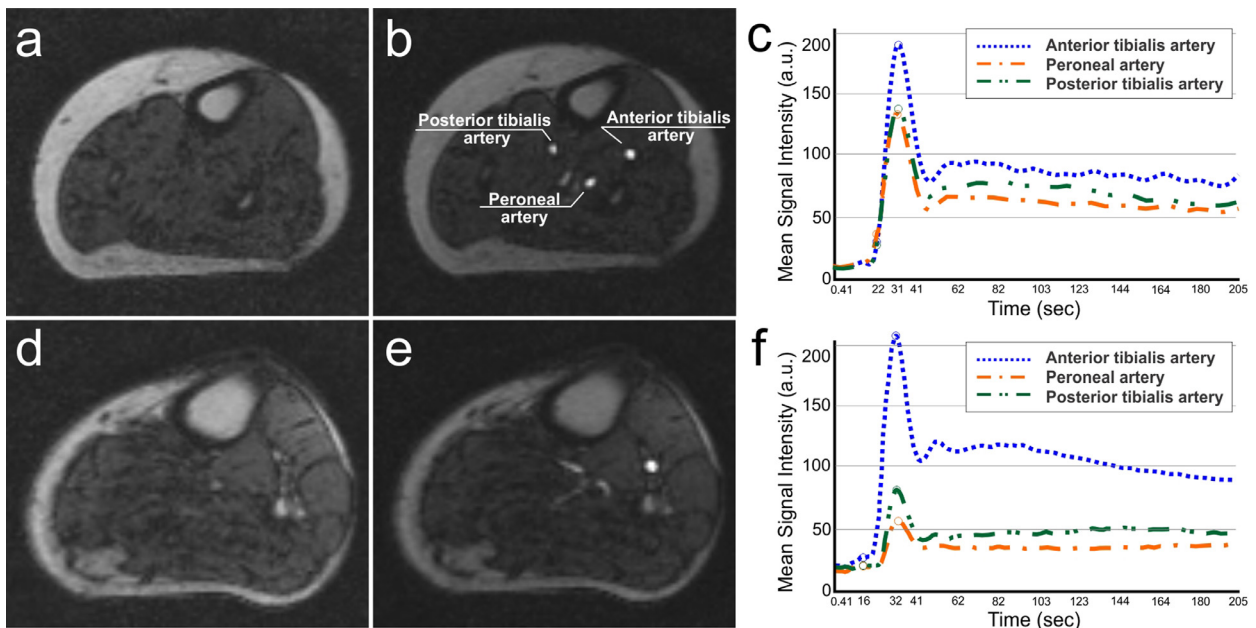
(a, d): Contrast-enhanced magnetic resonance images of a control and PAD patient at precontrast arrival; (b, e): Contrast-enhanced magnetic resonance images of a control and PAD patient peak arterial signal enhancement; (c, f): arterial signal enhancement from a control and a PAD patient (panels: curves represent the time points before contrast arrival, peak arterial signal enhancement, the minimum before the recirculation peak).
